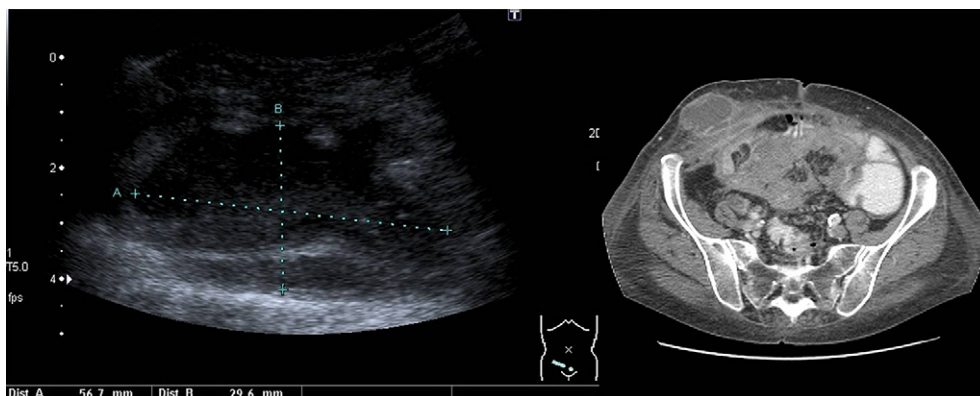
An abscess of the abdominal wall as seen on ultrasound and confirmed on the axial CT image.
